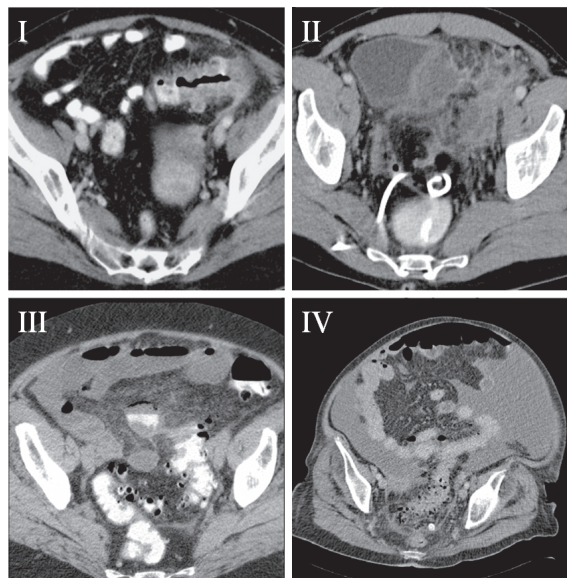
CT-scan images resembling the four Hughes stages
